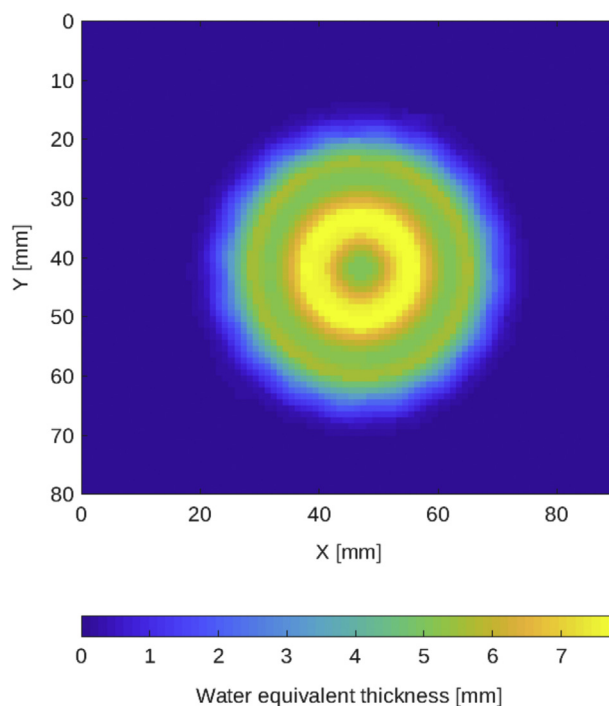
Water equivalent thickness of an optical surface marker estimated from proton radiography data. Note the color-wash scale in millimeter of water.
